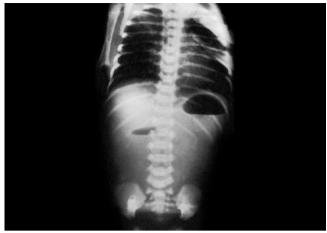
Plain abdominal radiograph showing a "double bubble"
